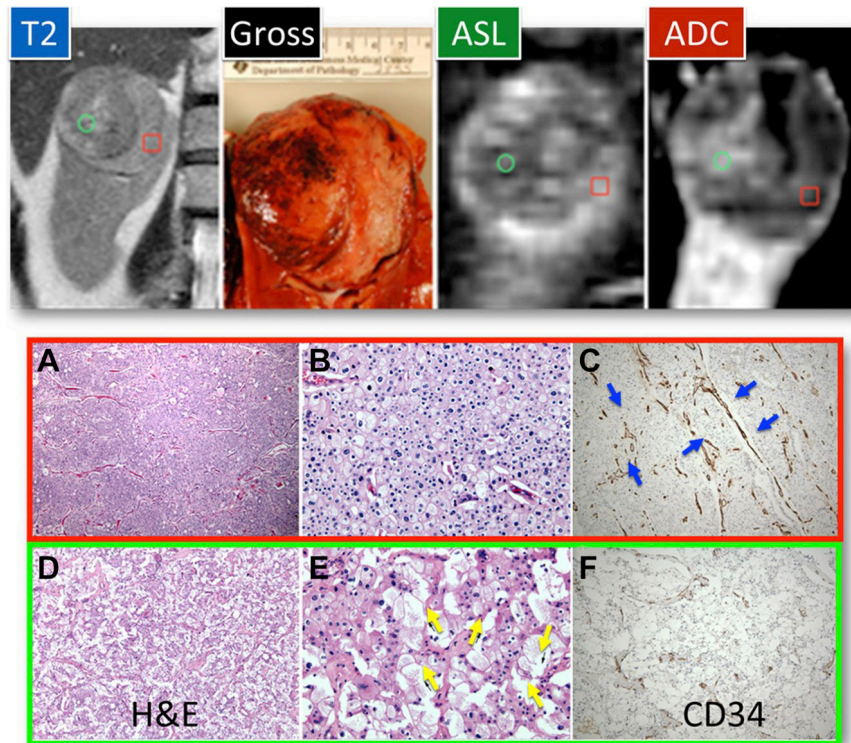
Quantitative MRI techniques for evaluation of tumor microenvironment in chromophobe renal cell carcinoma.
